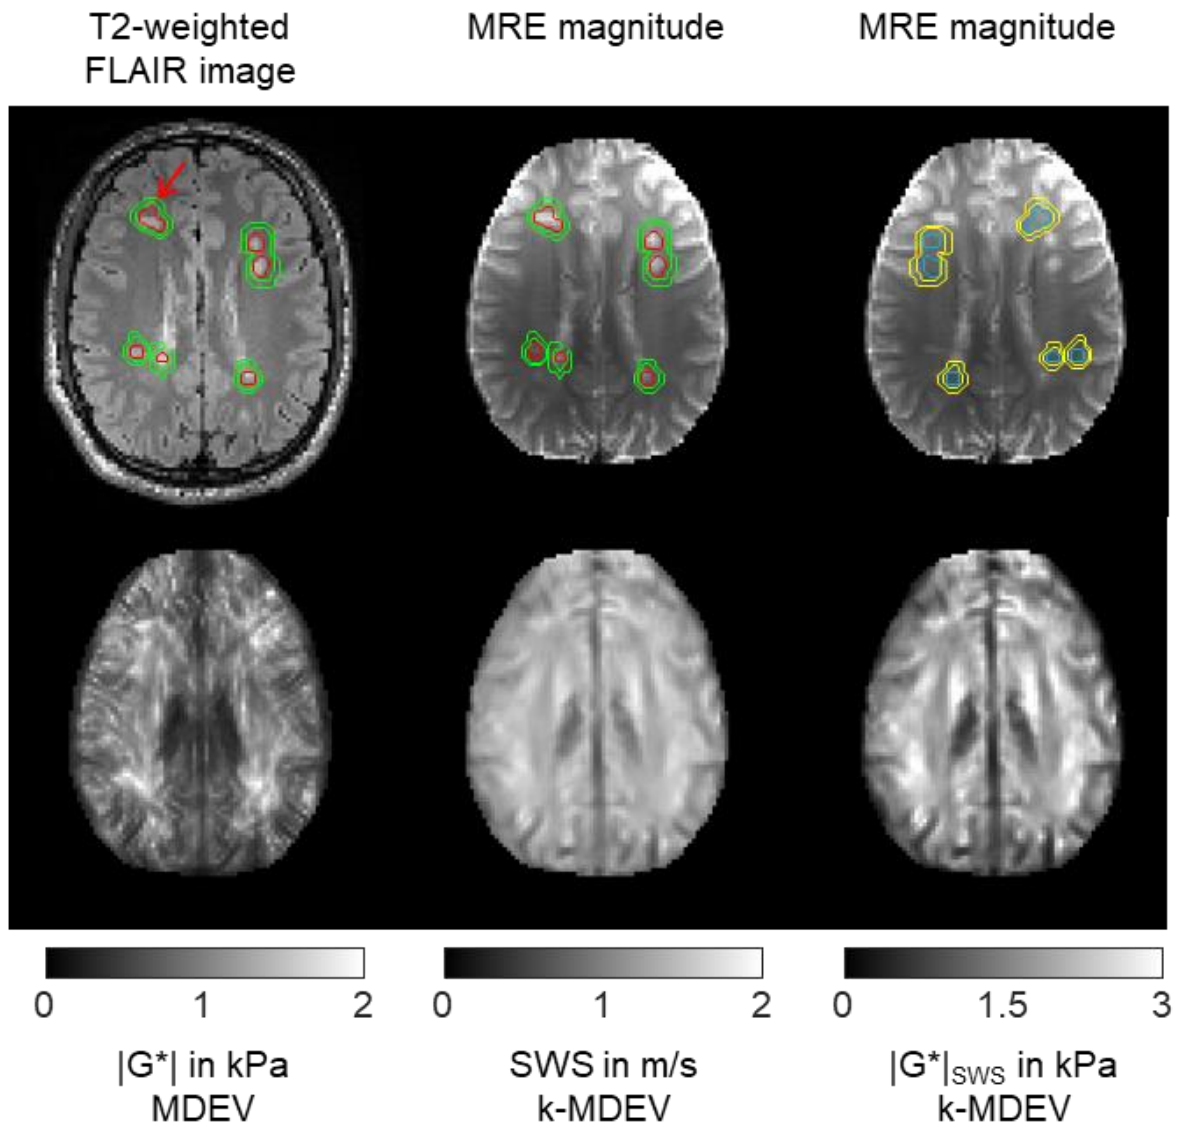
Representative images of T2-weighted FLAIR, MRE magnitude, MDEV based $|G^*|$ and k -MDEV based SWS and $|G^*|_{SWS}$ for a single subject in the same slice. Manually delineated MS lesion (red) are shown together with automatically generated surrounding tissue masks (green). Control regions (blue) are shown with their respective surrounding tissue (yellow). The red arrow indicates registration mismatch between MRE magnitude and FLAIR images. (edited figure from Herthum *et al.*, 2021⁶¹)
